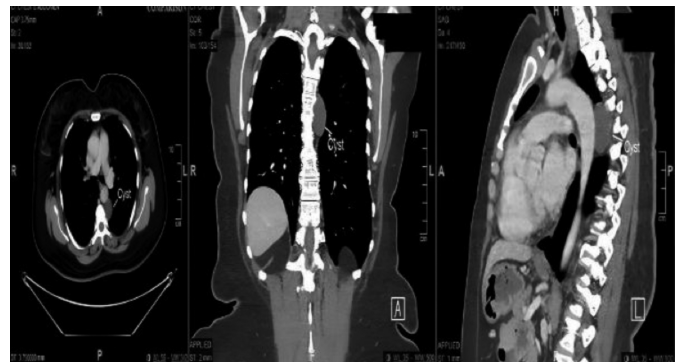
Axial, coronal and sagittal views from CT scan (from left to right) showing a posterior mediastinal paravertebral cyst.
